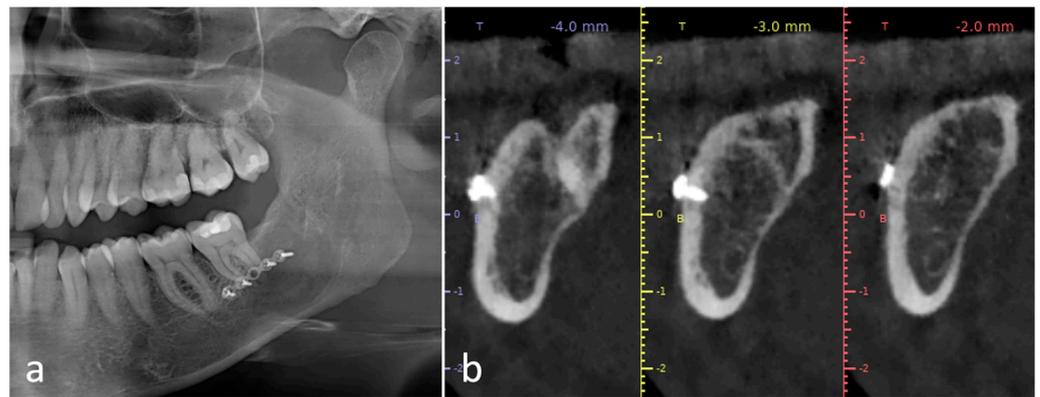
Case 1. Postoperative radiological follow-up at 1 year. (a) Detail of the panoramic radiograph; (b) details of the CT scan distally to tooth 37.
